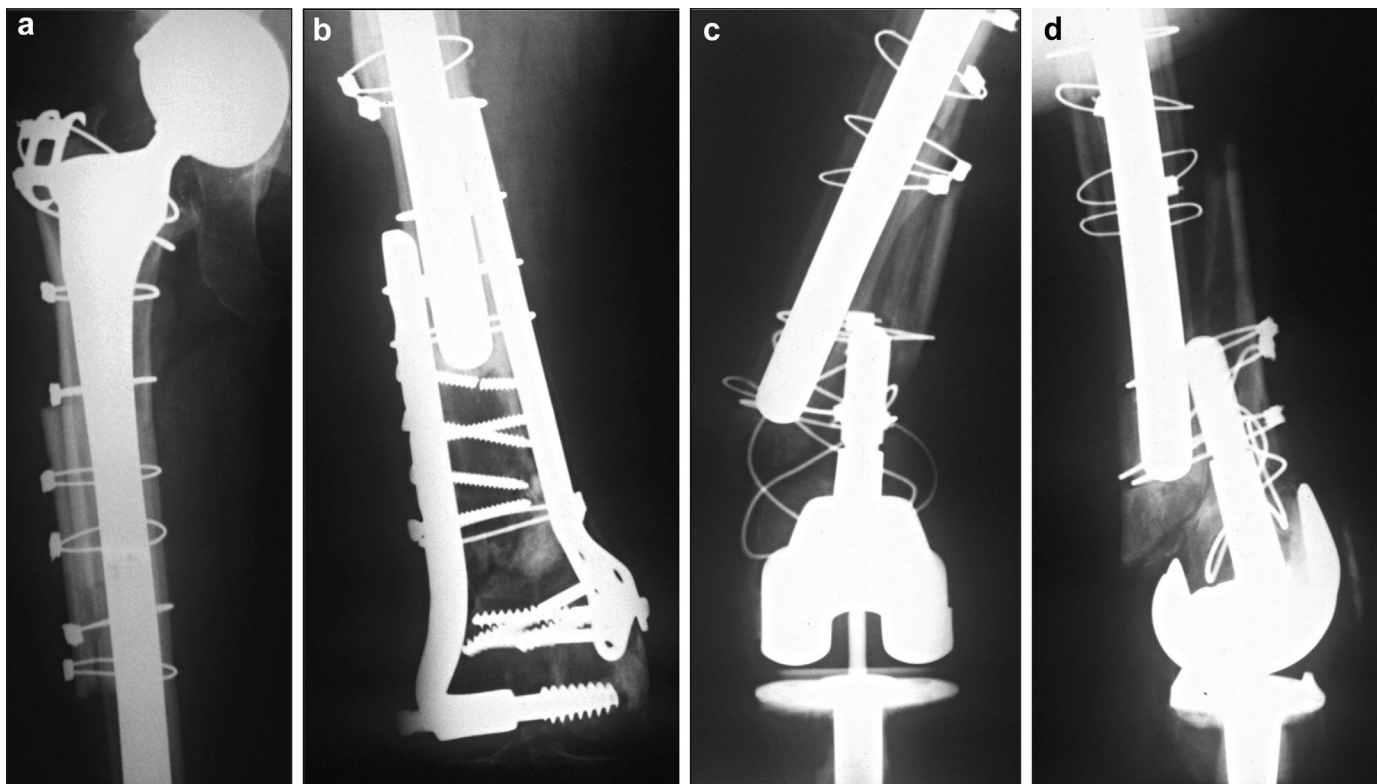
AP radiograph of right hip (a) and knee (b) after initial hip revision and internal fixation of the distal femur. AP (c) and lateral (d) radiographs of right knee after periprosthetic fracture following conversion to total knee replacement.
